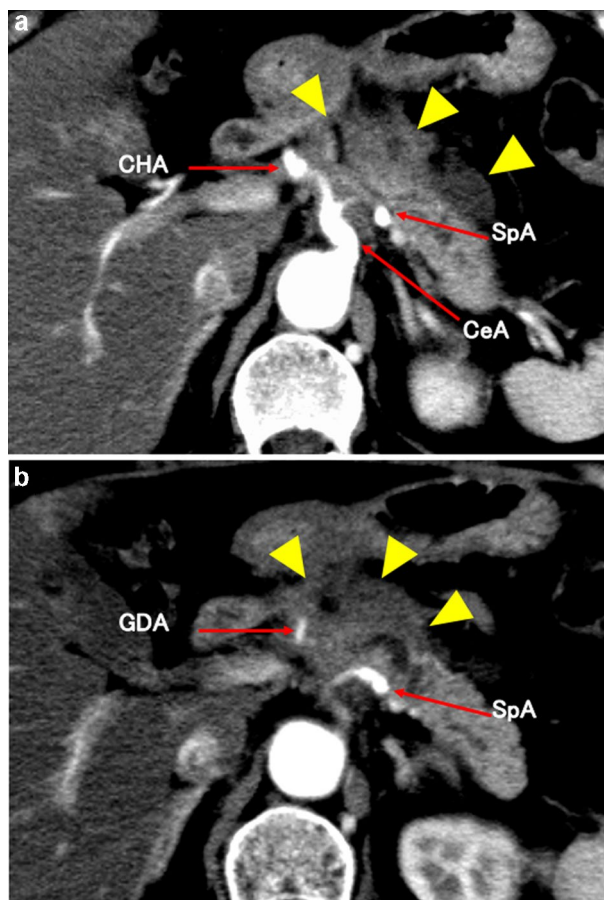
Initial multidetector computed tomography (CT). a A 40-mm irregular low-density mass is present in the body of the pancreas (yellow arrow). The tumor contacts the celiac artery, common hepatic artery, and splenic artery. b There is irregularity of the gastroduodenal artery due to tumor infiltration
